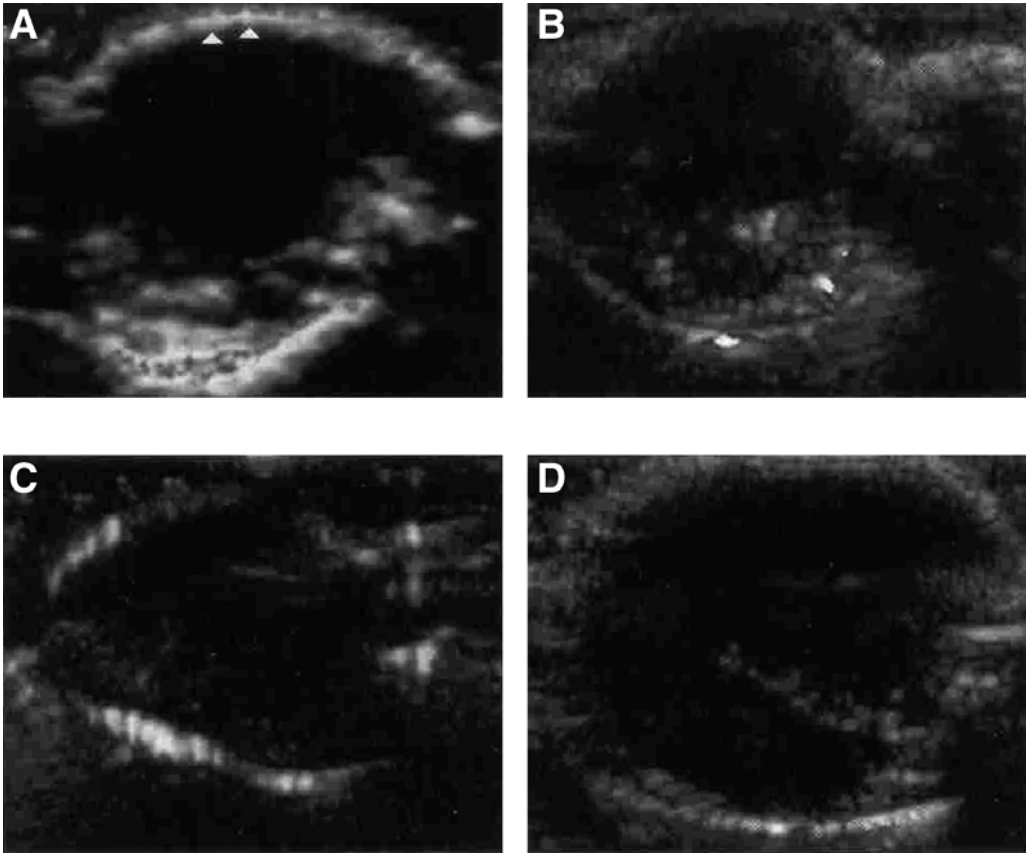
Representative power Doppler US images from (A) tumors in the control group, (B) tumors treated with TNF, (C) tumors treated with radiation therapy, and (D) tumors receiving combined TNF and radiation therapy. Depicted blood vessels are greatest in the periphery of the tumors (arrowheads in A). Treatment with radiation alone or TNF alone results in a decrease in depicted blood vessels. Combined therapy results in a greater decrease in depicted blood vessels.
